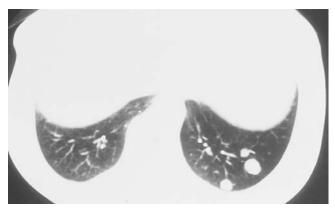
Computed tomography scan appearance of pulmonary metastases from parathyroid carcinoma.
